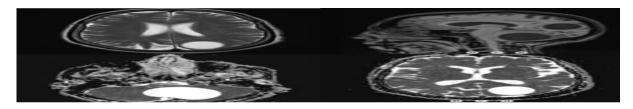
Cystic lesions are observed in the cerebellar hemisphere and left parietal lobe in axial T2 and sagittal T1-weighted sequences in cranial magnetic resonance imaging. No significant diffusion restriction was observed in diffusion-weighted sequences
